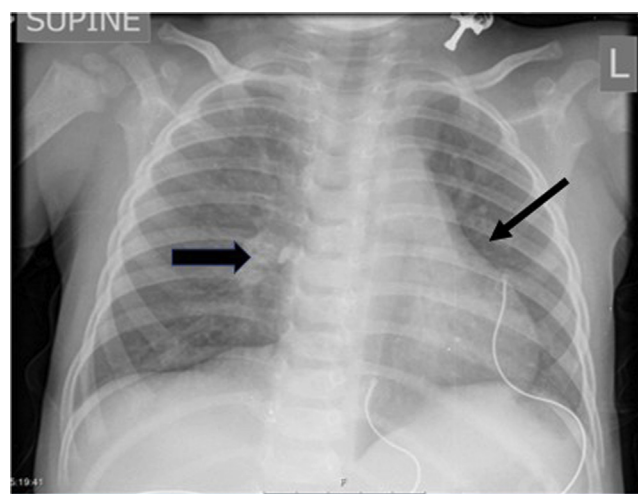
Chest radiography showing left lower lobe peribronchial markings (*thin arrow*) and a calcified shadow in the vicinity of the right main bronchus (*thick arrow*).
